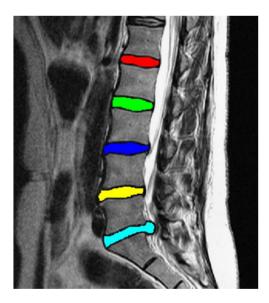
Manual segmentation of 5 consecutive intervertebral discs on T2-weighted magnetic resonance images, using the software ITK-SNAP.
